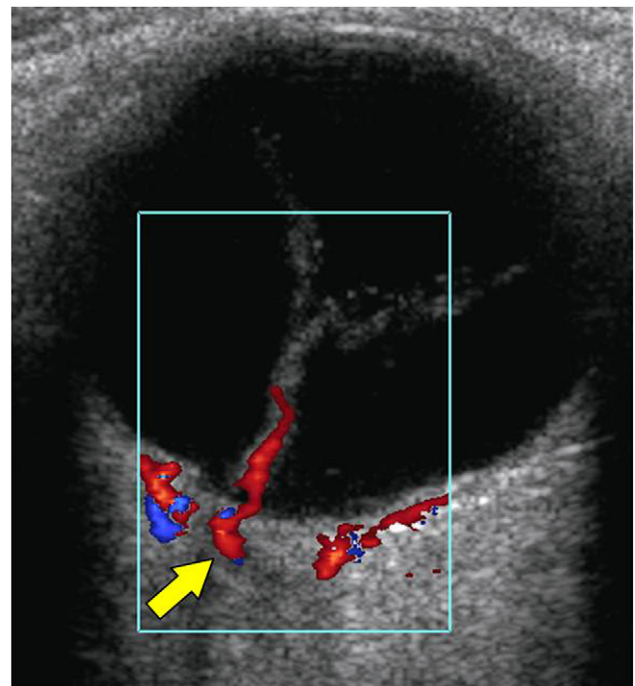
The easiest vessels to evaluate are those located at the end of the optic nerve. The ophthalmic artery (arrow) is located medially to the optic nerve and has a high resistance. The superior ophthalmic vein is located in the superomedial quadrant of the orbit and can be visualized in 90% of patients. It has continuous, low-resistance flow. The inferior ophthalmic vein is a smaller-caliber vessel and for this reason it is visualized less frequently. The central retinal artery and vein run parallel to the center of the distal segment of the optic nerve. Ultrasound diagnosis of complete detachment of the retina is generally easy because the retina remains anchored to its two attachment points (the optic nerve posteriorly and the ora serrata anteriorly).
